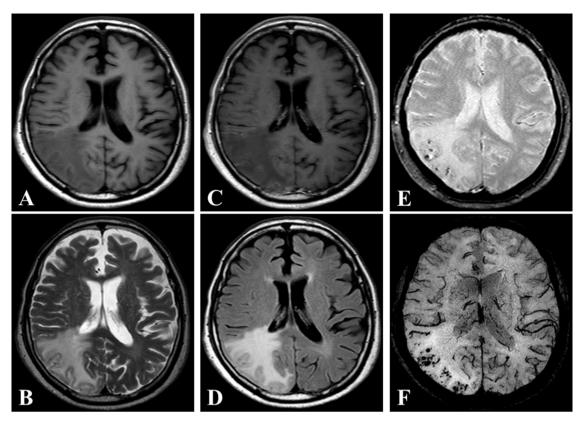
Images from preoperative axial T1-weighted imaging (A), T2-weighted imaging (B), gadolinium (Gd)-enhanced T1-weighted imaging (C), fluid-attenuated inversion recovery (FLAIR) (D), T2*-weighted gradient-recalled echo (T2*-GRE) (E), and susceptibility-weighted imaging (SWI) (F) show an area of abnormal intensity in the right occipital lobe. The lesion demonstrates no enhancement with Gd. T2*-GRE and SWI. images reveal multiple spotty cortical and subcortical hypointensities in the same region.
